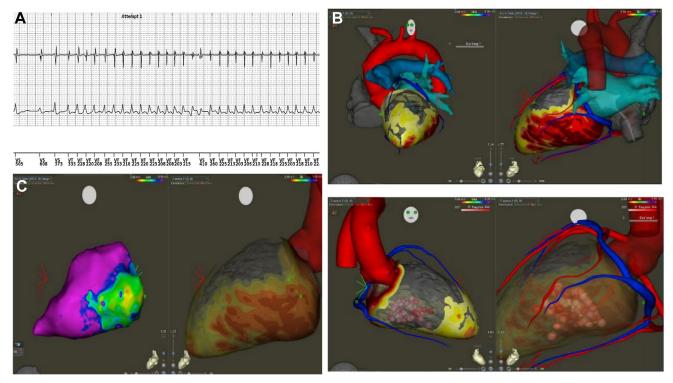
A: Single-chamber device electrogram demonstrating ventricular tachycardia (VT) in the ventricular fibrillation zone. B: inHEART coronary computed tomography angiography used for VT ablation planning. C: Left ventricle (LV) unipolar voltage map demonstrating scar in the inferior LV.
